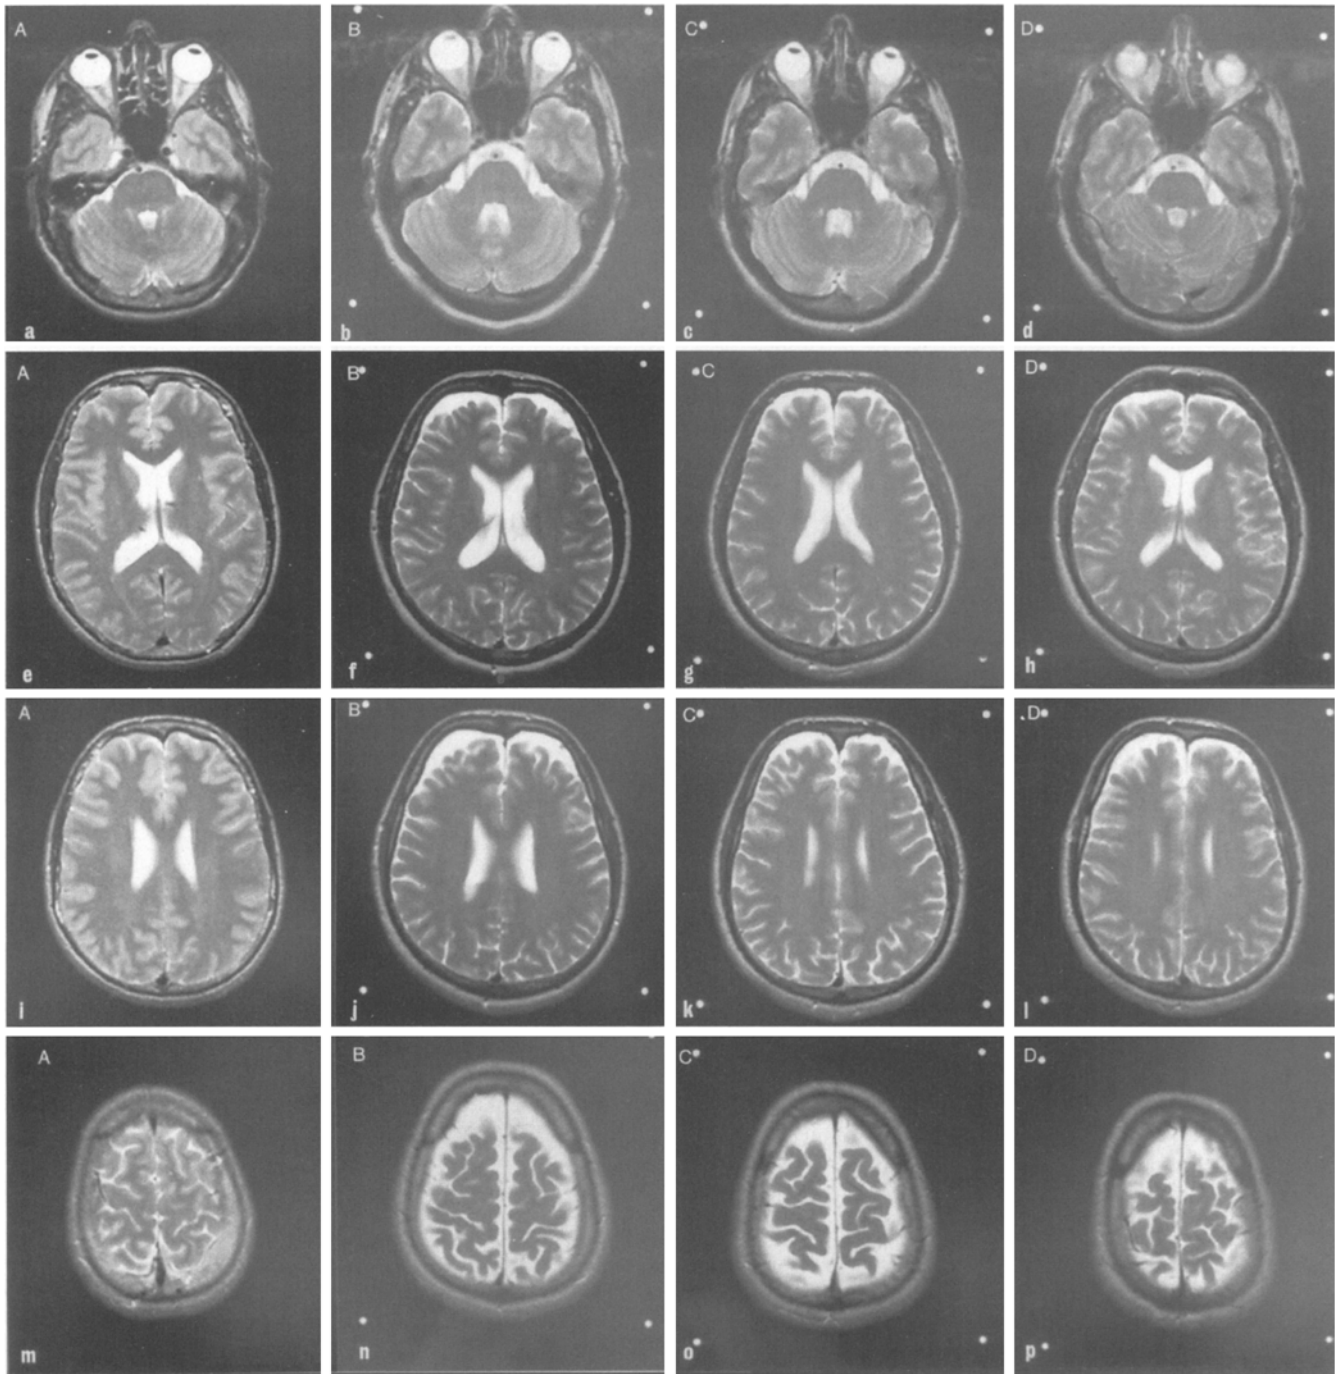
a–p. Transaxial T2-weighted MR images of four people (placed vertically). A 37-year-old healthy male control is presented in the first column (A). The morphological changes are close to identical in all three triplets (B, C, and D). The cerebello-pontine cisterns are markedly enlarged b–d; so is the subarachnoid space in the frontoparietal region f–h, j–l, n–p. The ventricular system is at the upper limit of the normal variation (Evans Index = 0.30 in C and D). The sulci at the convexity are not enlarged
